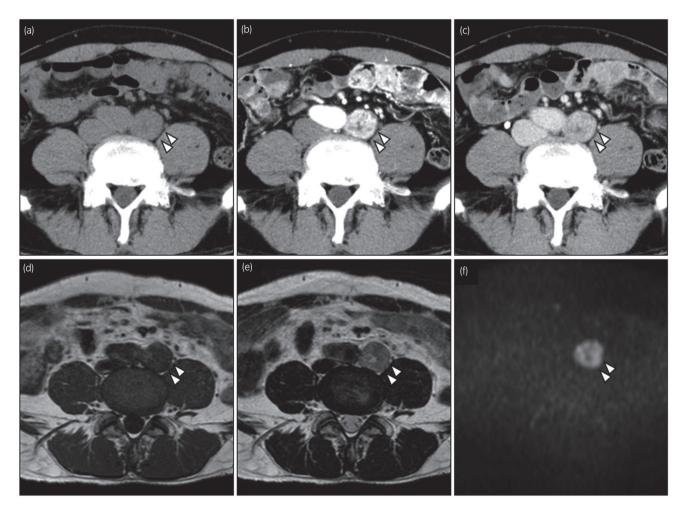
(a) Axial unenhanced CT demonstrates a well-defined, 25-mm soft tissue mass in the left para-aortic region (arrowheads). (b) Arterial and (c) venous phase IV contrast-enhanced CT images show avid, heterogeneous enhancement in the arterial phase followed by mild washout in the venous phase. The mass exhibited iso-signal intensity on (d) T1-weighted images, (e) moderate-to-high signal intensity on T2-weighted images, and (f) high signal intensity on diffusion-weighted images on MRI.
